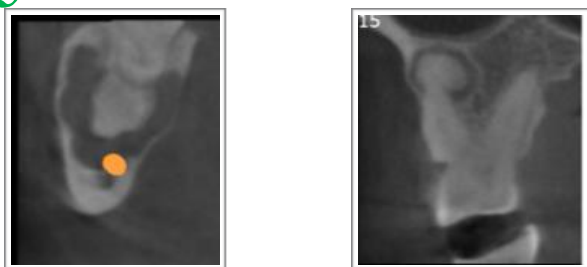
4 a) showing images of mandible with inferior displacement of mandibular canal with thinning cortical plates, b) showing hypodense areas surrounding hyperdense areas in periapical areas and few cystic lesions and expansion of mandible and thinning of cortical plate.
